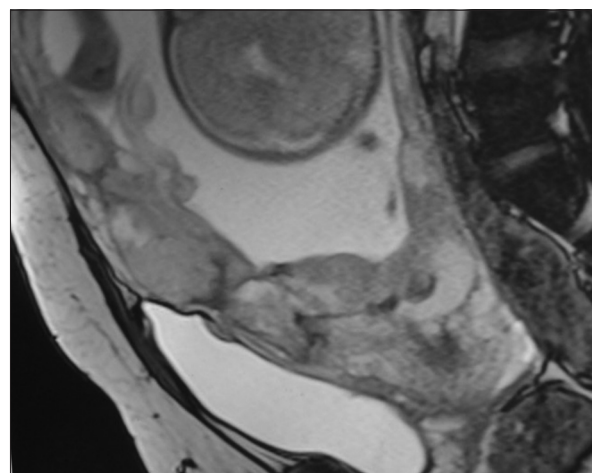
Sagittal T2-weighted placenta percreta without interface between bladder and uterus (32 weeks gestation)
